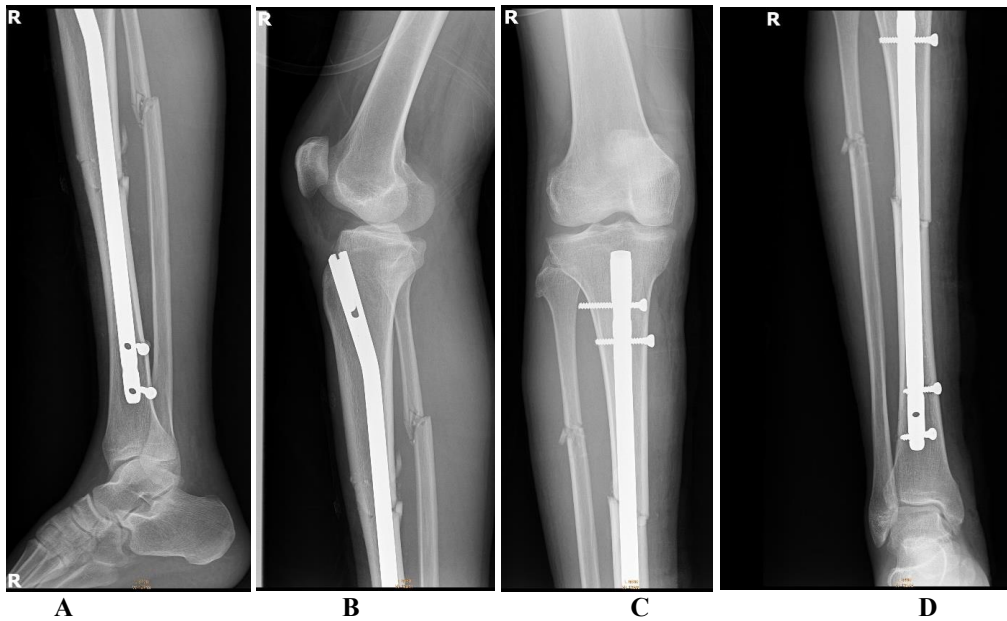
(A) Anterior posterior X-ray of the Tibia/Fibula exposing the ankle joint (B) Lateral X-ray view of the Tibia/Fibula exposing the ankle joint (C) Lateral X-ray view of the Tibia/Fibula exposing the knee joint (D) Anterior posterior X-ray of the Tibia/Fibula exposing the knee joint images revealing callus formation with an increase in density with normal implant integrity
